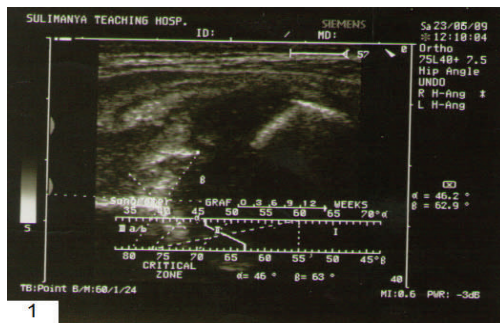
ultrasound of left hip in a female baby with bilateral DDH, Graf IIc (1) treated with Pavlik harness, changed after three months to Graf I (2).
